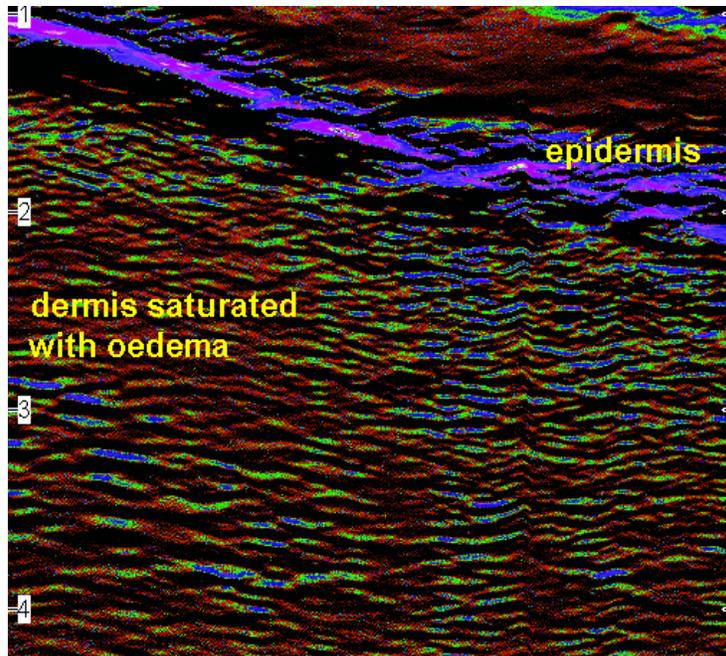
The ultrasound scan of one volunteer's pressure sore. The images shows that the deeper layers of the skin is saturated with oedema
